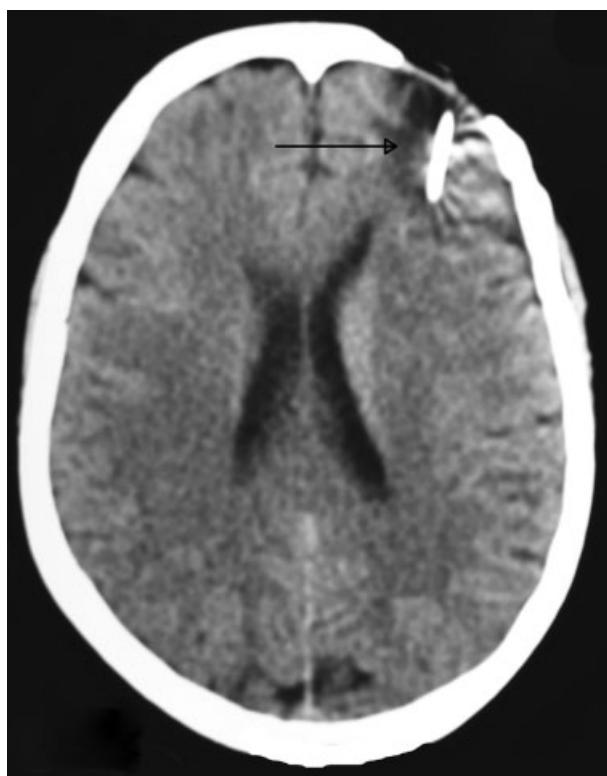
Noncontrast computed tomography brain shows foreign body (needle [arrow]) in the left frontal cortex.
